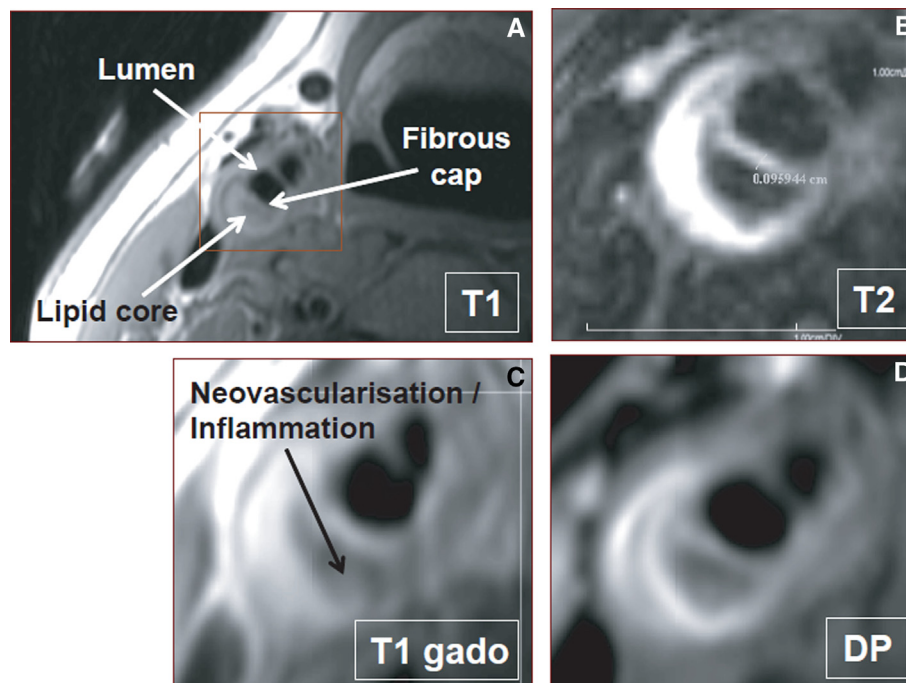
High-resolution magnetic resonance imaging of an asymptomatic patient's right internal carotid artery plaque, cross-sectional views. This patient has a 50% stenosis. (A) T1-weighted image, showing a thick fibrous cap and large lipid core, easier to depict on (C) the corresponding postgadolinium injection T1-weighted image (T1 gado). (D) Proton density image (DP), showing an isointense core. (B) A drop in relative signal intensity on the T2-weighted image (compared with other sequences) confirms the presence of a lipid-rich necrotic core. The fibrous cap measures more than 900 μm in its centre. (C) After gadolinium injection, plaque enhancement is observed in the posteromedial aspect of the plaque, which suggests neovascularization or inflammation (T1 gado). This figure is available in colour online at <http://carjonline.org/>.
